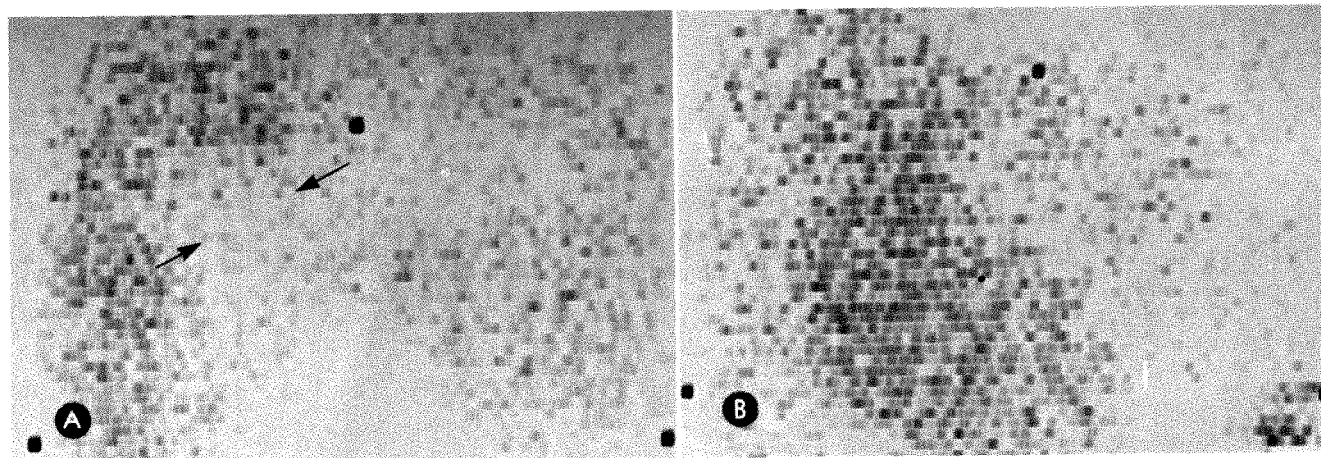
Liver scintigraphy with ^{131}I rose bengal. *A*, Immediate scintigram revealing large defect at junction of right and left lobes. *B*, Scintigram at 24 hr showing accumulation of radioactivity in area of previously noted defect, indicative of bile-containing structure.
